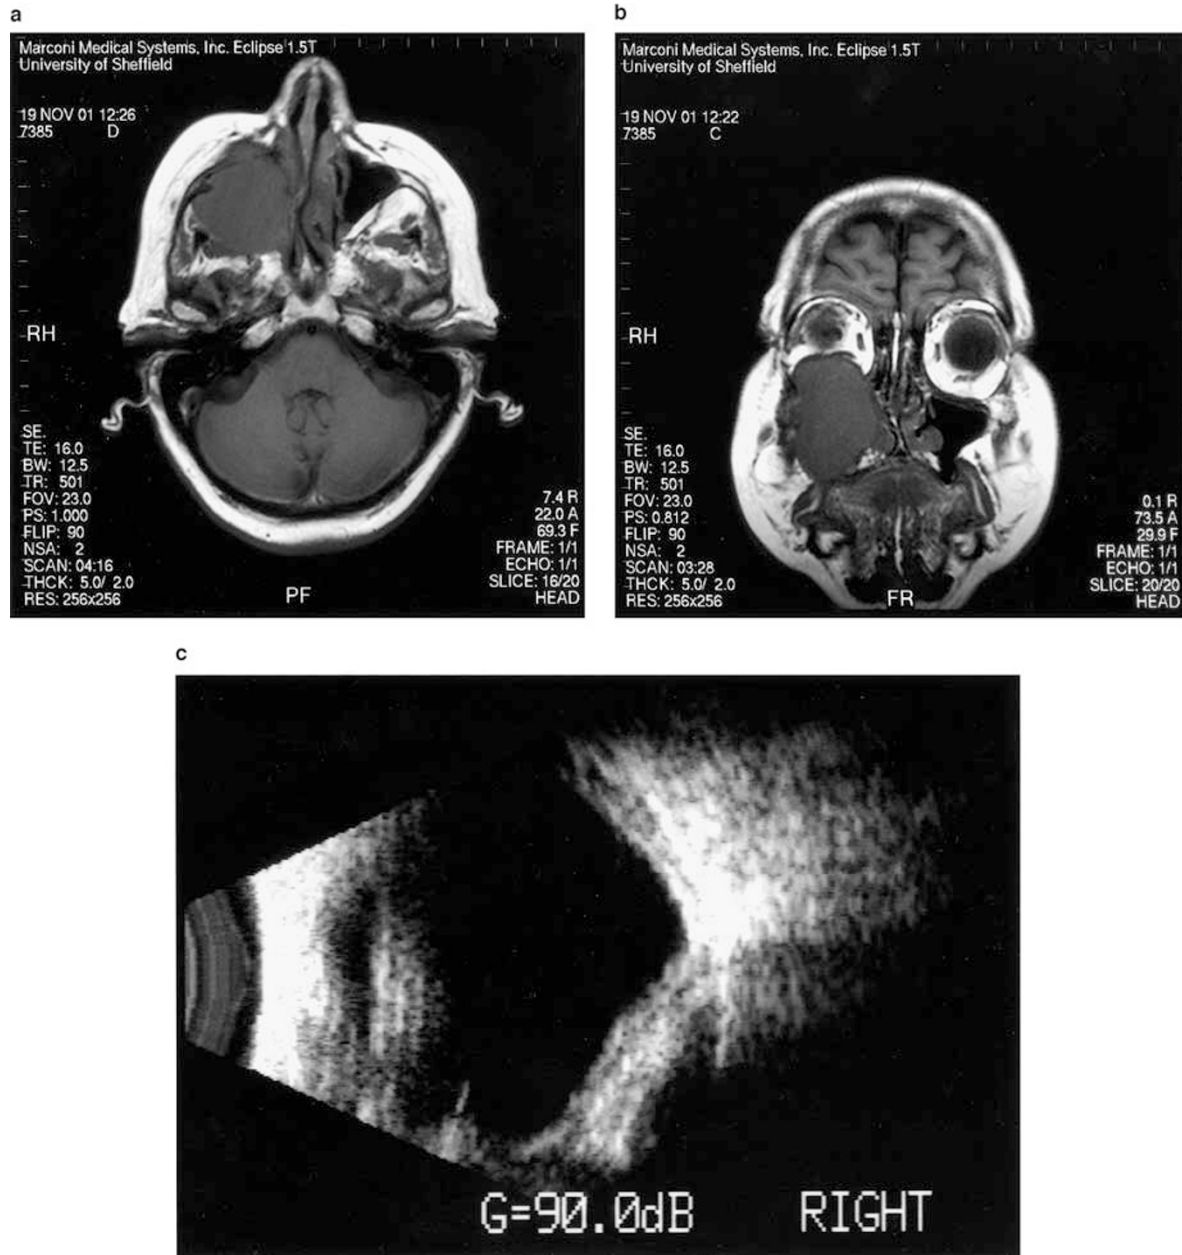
(a) and (b): MRI show complete opacification of right maxillary sinus with expanding mass in all directions. (c) Ultrasound B scan with large orbital mass indenting the inferior aspect of the eyeball.
